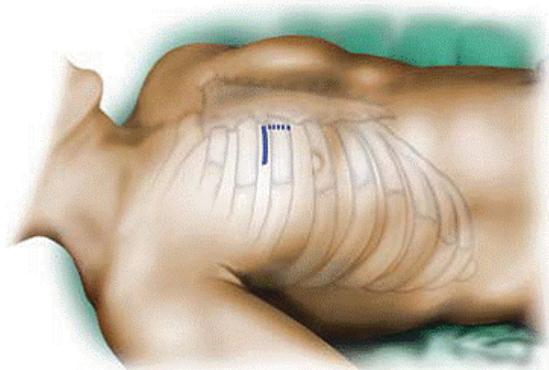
A 5 cm transverse parasternal incision is made over the right second-third intercostal space, and the lower costochondral cartilage is transected.
